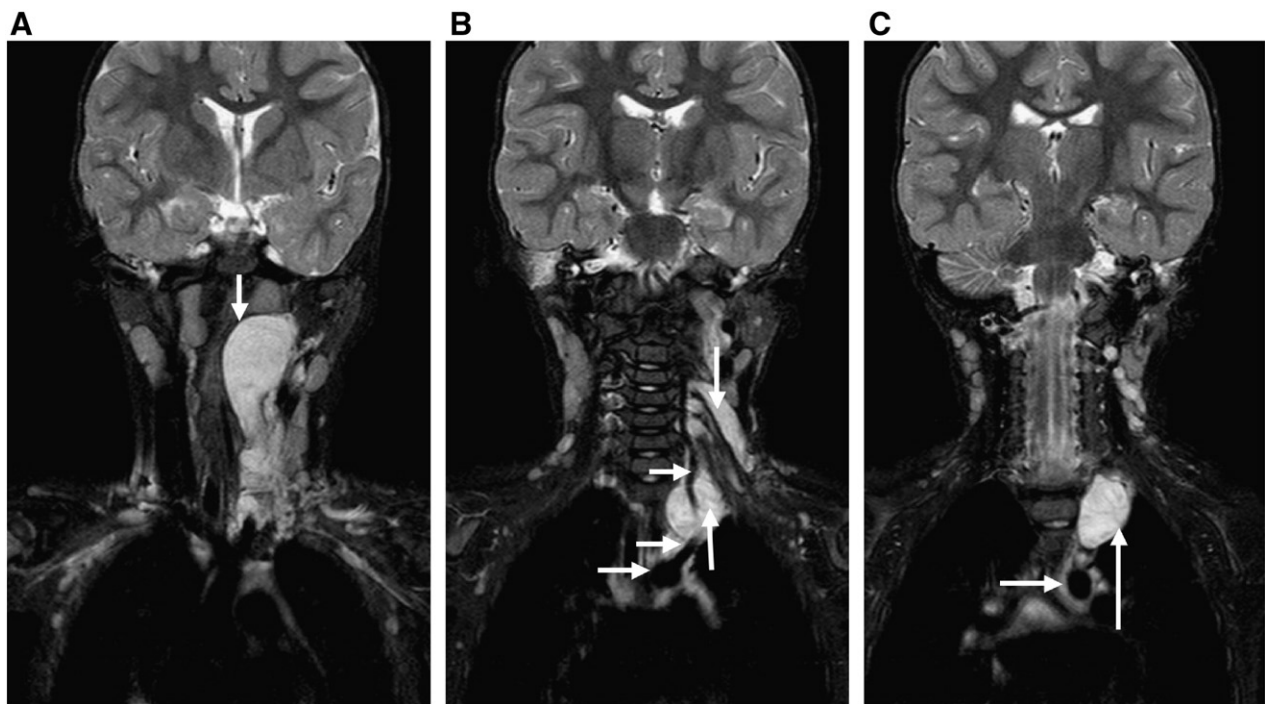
Coronal magnetic resonance imaging sections from head to upper thorax showing (A) the cranial portion of the lesion (arrowed) in the nasopharynx around the level of the skull base; (B) the intermediate part of the tumor (lower vertical arrow) abutting the aortic arch (lowest horizontal arrow), encasing the left subclavian origin (middle horizontal arrow) and left vertebral artery (upper horizontal arrow) and adjacent to the brachial plexus roots (upper vertical arrow); and (C) the thoracic component of the mass (vertical arrow) and the adjacent aortic arch (horizontal arrow).
